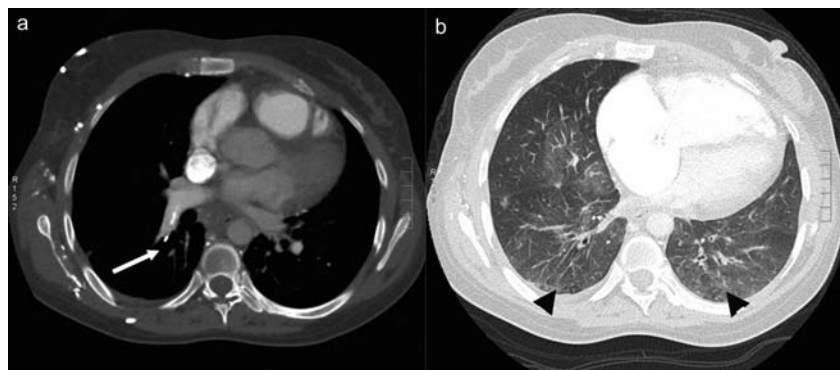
(a) Helical slice through mediastinal window of computed tomography (CT) chest showing dislodgement of ventriculo-atrial shunt tube caudally in the right pulmonary artery. (b) Helical slice through lung windows of CT chest showing arrows that point to mosaic pattern of lung attenuation suggestive in this case of vascular lung disease beyond the third-generation bronchial tree.
